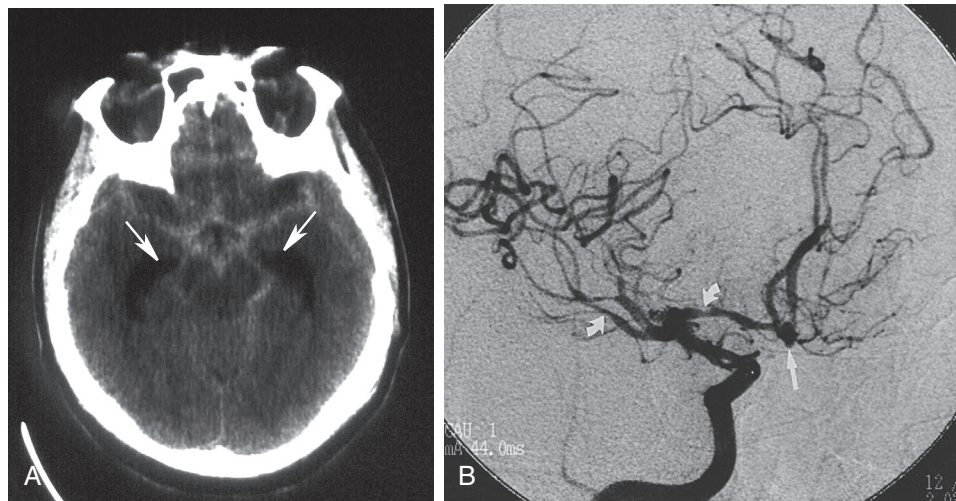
■ Subarachnoid hemorrhage and aneurysm. A, Axial non-contrast-enhanced computed tomography scan of head reveals high density (blood) replacing normal low density of cerebrospinal fluid within suprasellar cistern and subarachnoid spaces, indicating subarachnoid hemorrhage. Also note dilated temporal horns (arrows), indicating acute hydrocephalus. B, Right internal carotid artery angiogram demonstrates presence of congenital anterior communicating artery aneurysm (arrow), as well as vasospasm (curved arrows).
